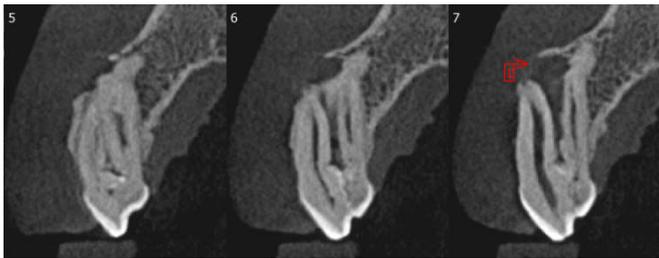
Sagiital cross sections revealing periapical radiolucency and breach in continuity if buccal cortical plate
